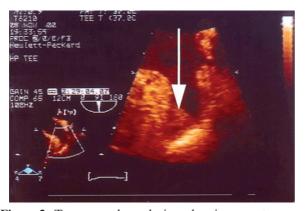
Transoesophageal view showing spontaneous echo contrast and multiple left atrial appendage thrombi (arrow).
